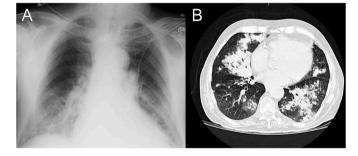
Patient 2 radiological findings. A: Chest radiograph (posteroanterior incidence) shows increased cardiothoracic ratio and bilateral nodular opacities, in both lower lung fields, more evident in the right lung. B: Thorax CT scan shows bilateral multifocal consolidations with air bronchogram and ground-glass densifications.
